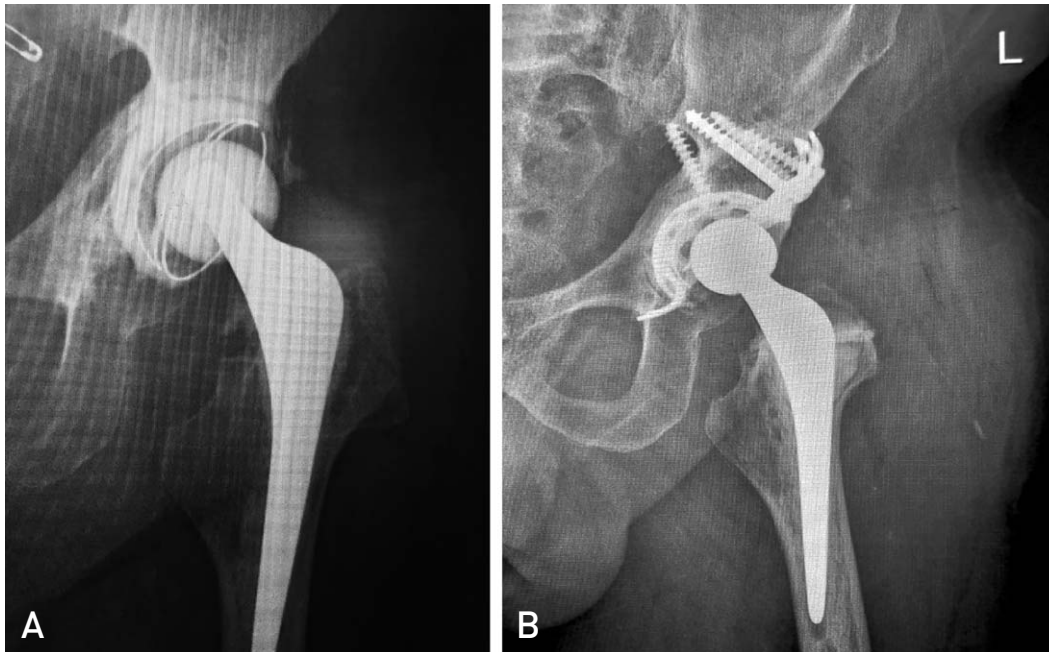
(A) Radiograph of early failure of a cemented total hip replacement (THR) at four years postoperative in a 45-year-old amputee. Core biopsy result suggested low-grade infection. (B) Radiograph at 12 months post impaction bone grafting and good incorporation of graft with a Cup-Cage system.
